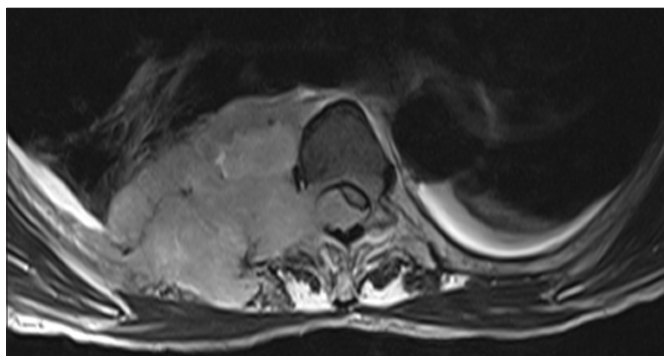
A magnetic resonance image (MRI) of a patient who presented with lower-limb weakness secondary to a vertebral plasmacytoma.
